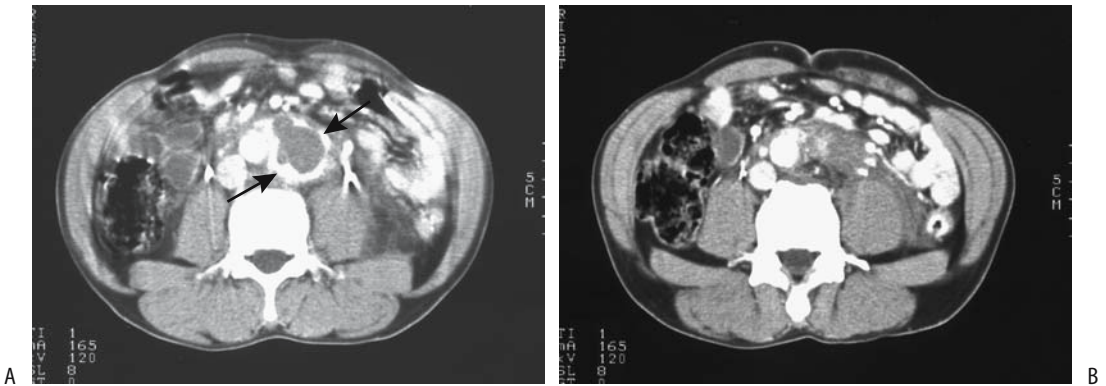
Spontaneous rupture of paraganglioma. A: Contrast-enhanced CT shows a retroperitoneal tumor with peripheral enhancement (arrows). B: A more caudad scan identifies left para-aortic fluid and infiltrate, mimicking a ruptured aortic aneurysm. (Source: Rha SE, Byun JY, Jung SE, Chun HJ, Lee HG, Lee JM. Neurogenic tumors in the abdomen: tumor types and imaging characteristics. *Radiographics* 2003;23:29–43, with permission from the Radiological Society of North America.)
